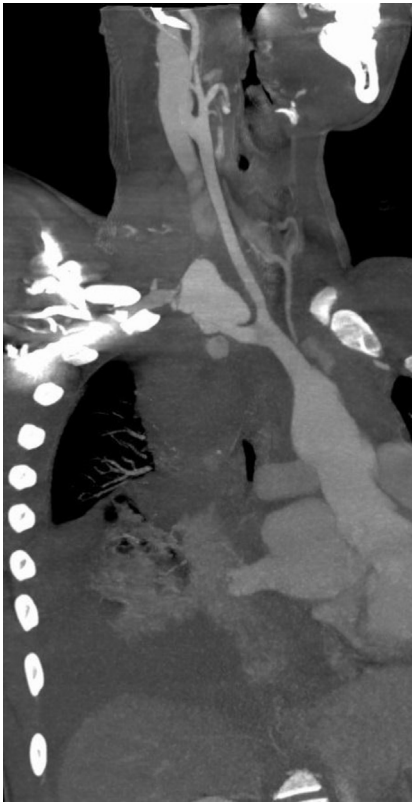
Reconstructed computed tomography image shows the ruptured right subclavian artery and the development of a pseudoaneurysm with a 4-cm diameter.
